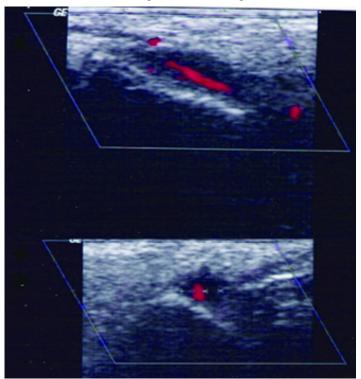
Giant cell arteritis. Color-Doppler sonography demonstrating the 'halo sign' as the hypoechoic area around the temporal artery in longitudinal (upper panel) and transverse (lower panel) views.
